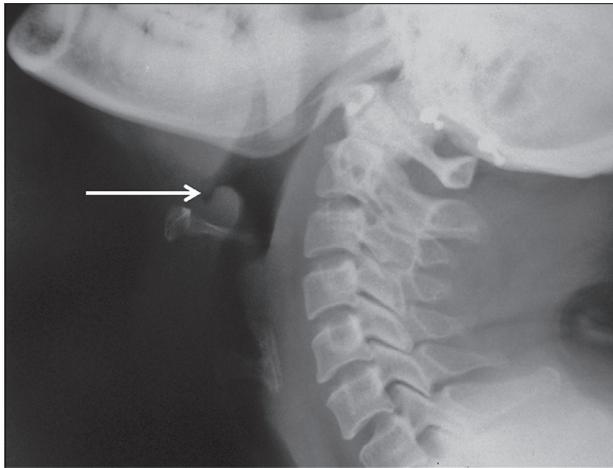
Lateral soft tissue radiograph of the neck showing “thumb sign” (arrow), suggesting a severely inflamed, oedematous and enlarged epiglottis
